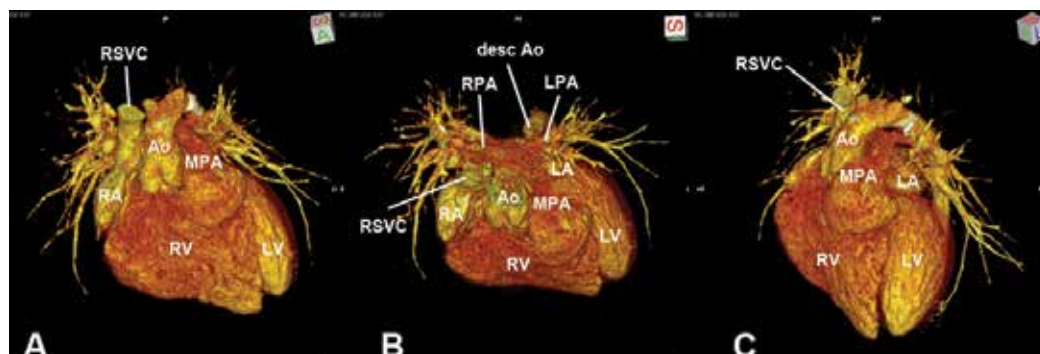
Three-D CT reconstruction six years after Modified Rastelli operation; no stenosis was observed at the site of free graft. The natural spiral arterial trunks with harmonic growth of their branches were evident. Abbreviations see Figure 7.
